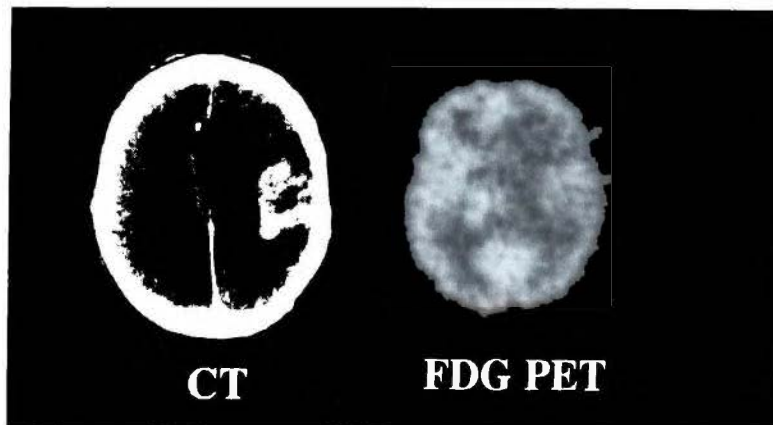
X-ray computed tomographic (CT) image and positron emission tomographic (PET) image of a 49-year-old male patient with recurrent brain glioma. The CT image shows that tumor occupies a large volume on the right side of the brain, with structures at the midline pushed into the left cerebral hemisphere by the tumor volume. The PET image was obtained by infusing a radioactive analogue of glucose (^{18}F -fluoro-deoxyglucose) into the blood and imaging the location of radioactivity several minutes later. This analogue of glucose accumulates in cells, because it is taken up across the cell membrane in the same way as glucose, but cells are unable to further metabolize it. The PET image, which is brighter in the tumor, shows that tumor takes up more glucose than surrounding tissue on that side of the brain, probably because glucose metabolism by tumor is inefficient. However, note that glucose uptake by the entire right side of the brain is lower than by the left side of the brain, probably because blood flow to the right side of the brain is reduced by intracranial pressure. (Photograph courtesy of Dr. Michael Graham, University of Washington School of Medicine.)
